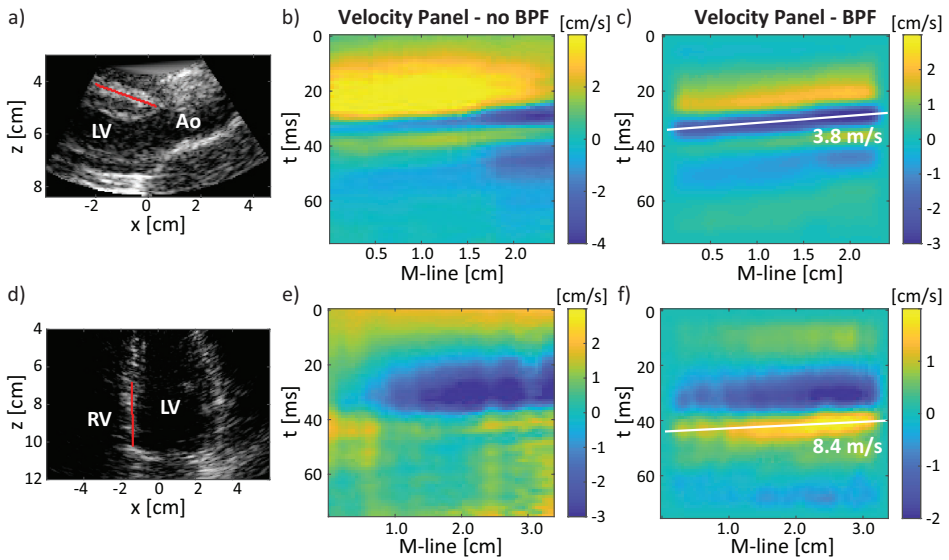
Example of an M-line drawn in a parasternal (a) and apical view (d) measurement and the corresponding velocity panels ((b) and (e)). A bandpass filter from 15 – 100 Hz was applied and a Radon transform was used to determine the propagation speeds ((c) and (f)). Abbreviations: LV: left ventricle, Ao: aorta, RV: right ventricle, BPF: bandpass filter, slowtime: time between frames.
